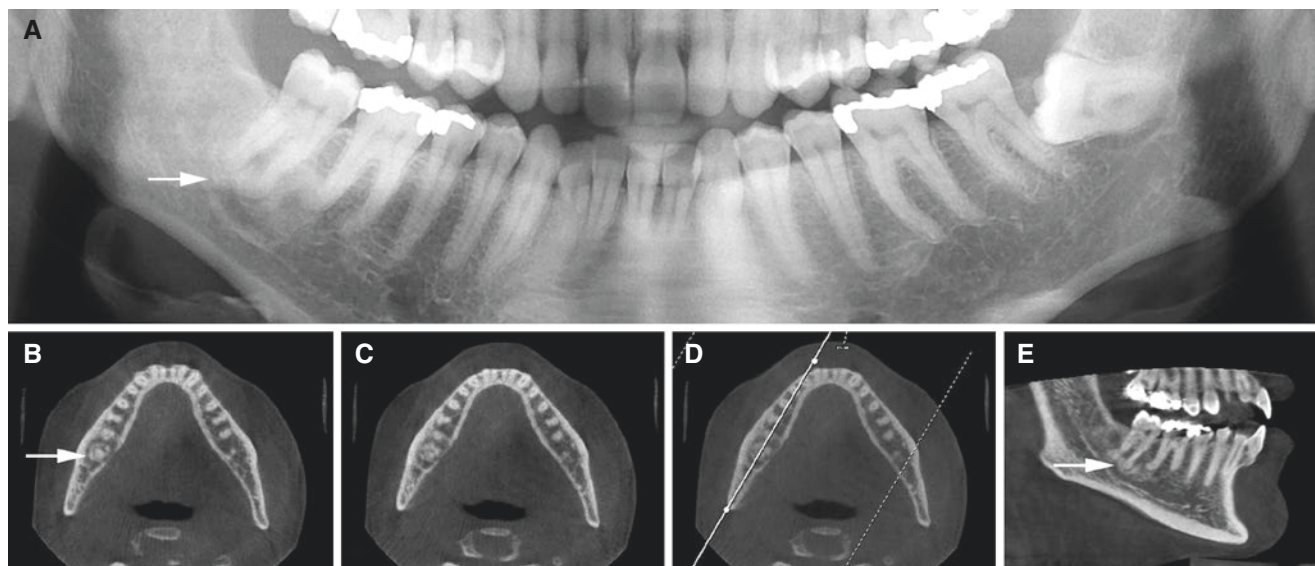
Focal osseous dysplasia, mandible; 35-year-old female with incidental finding. Vital teeth. (A) Panoramic view shows irregular radiolucent and radiopaque periapical bone structure (*arrow*). (B)
